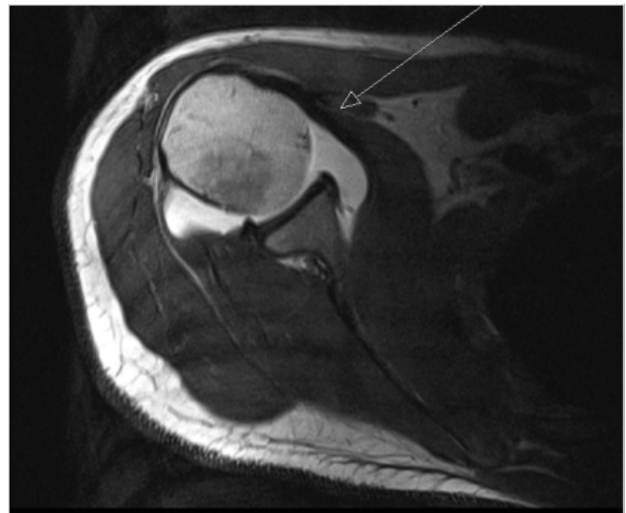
MRI Arthrogram. T1 Fat saturated axial with intra articular gadolinium showing hypoplastic bicipital groove and absent long head of biceps tendon.
